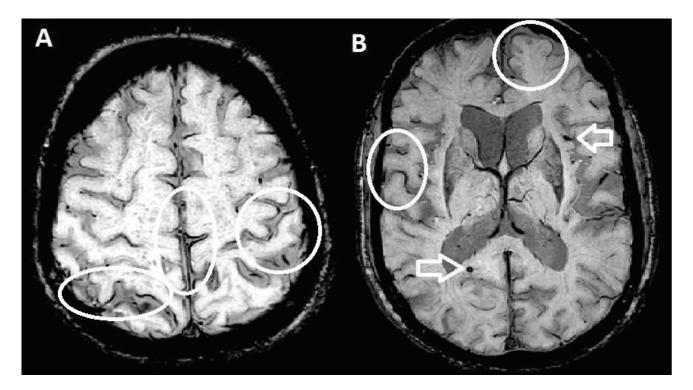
MRI Brain Susceptibility Weighted Imaging(SWI) showing areas of superficial cortical siderosis (A and B) appearing as black lines and small black dots representing cortical microhemorrhages(B)
